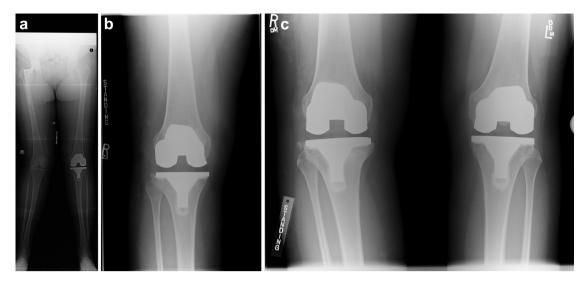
(a) Anteroposterior (AP) long leg preoperative radiographs from February 2009 (b) AP right knee at 6 weeks postoperative (c) AP bilateral knees at 1 year postoperative (d) AP and lateral radiographs first demonstrating tibial tray fracture in July 2010 (e) AP long leg radiographs 1 month after revision procedure (f) AP bilateral knees at 5 years after revision procedure.
